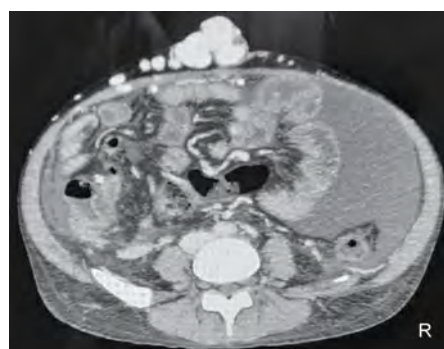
Computed tomography angiography showing dilated collaterals in the paraumbilical region draining into the systemic veins (caput medusae appearance)
